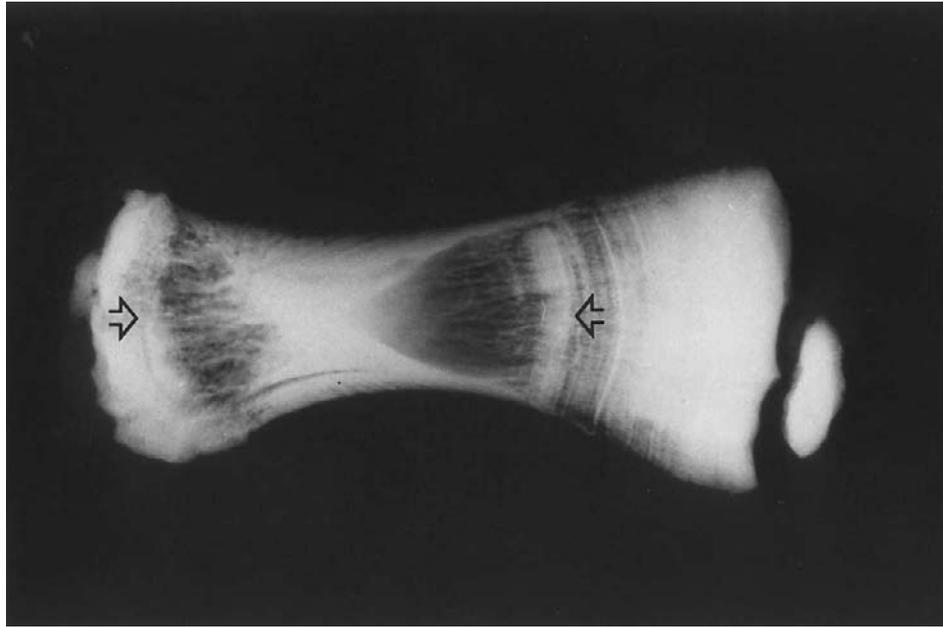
This radiograph shows a phalangeal bone, obtained at autopsy from a 7-year-old with malignant osteopetrosis treated with calcitriol. Note the presence of the original bony template (endobone, between the arrows) which was present at birth and never remodeled. The radiograph shows the presence of mineralized bone which has been laid down outside of this original bone/cartilage template without the underlying template having been resorbed.
